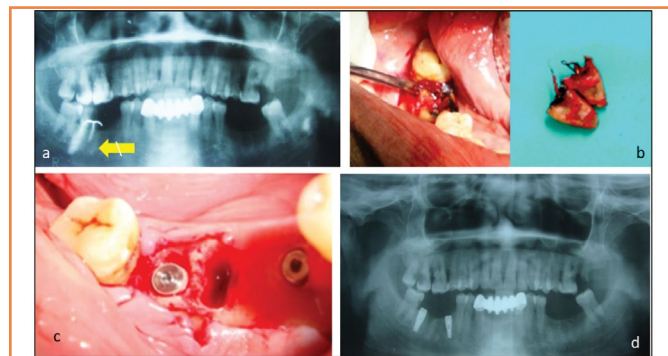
A case of immediate implant placement a) Pre-operative orthopantomogram (OPG) with arrow showing 46 indicated for extraction. b) Extraction of the root stump. c) Immediate implant placement. d) Post-operative OPG showing implant placement
